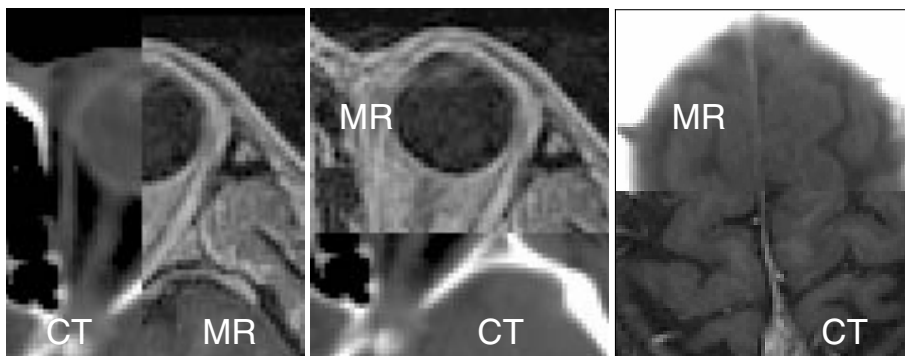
Image-image visual validation using split-screen displays of native MR and reformatted CT study
